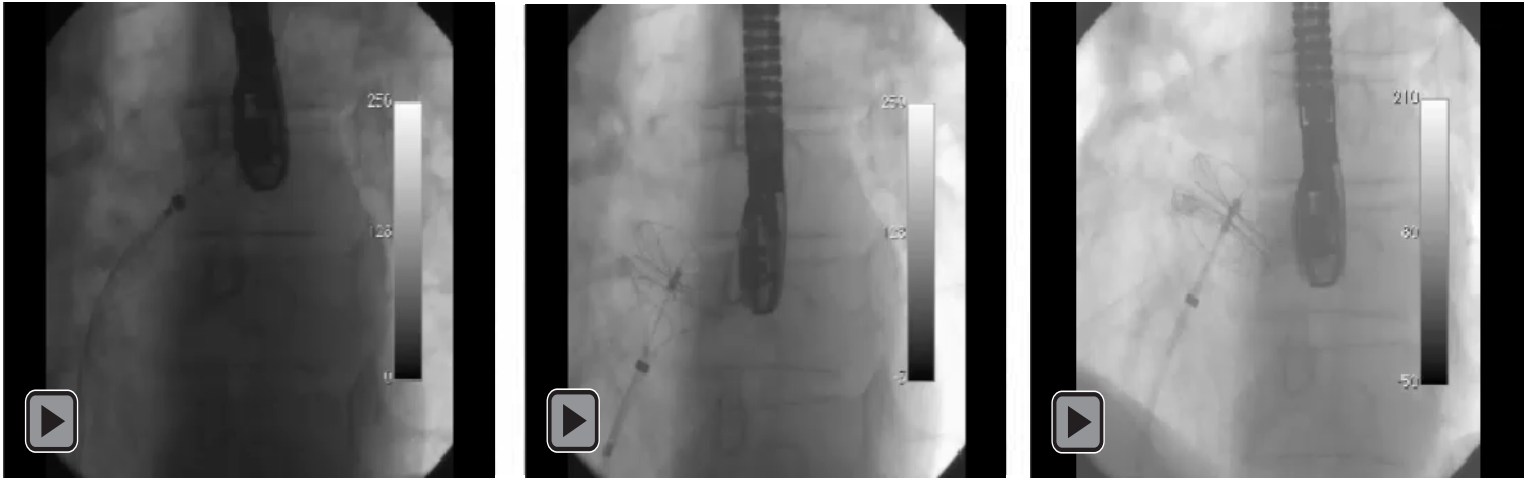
Fluoroscopic views in left anterior oblique. Procedure is performed under fluoroscopic and intracardiac echocardiographic views. Left: left atrial disc is opened; Middle: Left and right discs are opened and placed across the septum; Right: occluder is released and properly placed.
